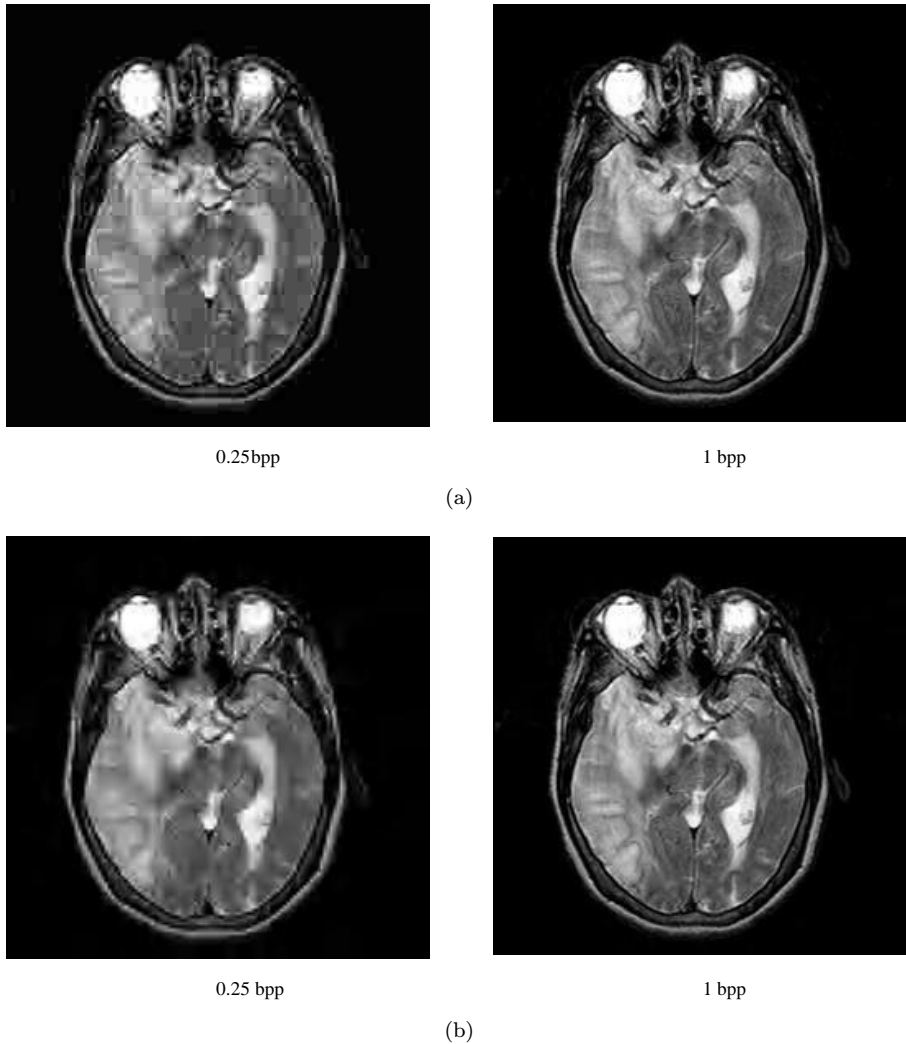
Reconstructed sample MRI image using (a) JPEG and (b) JPEG-2000.
